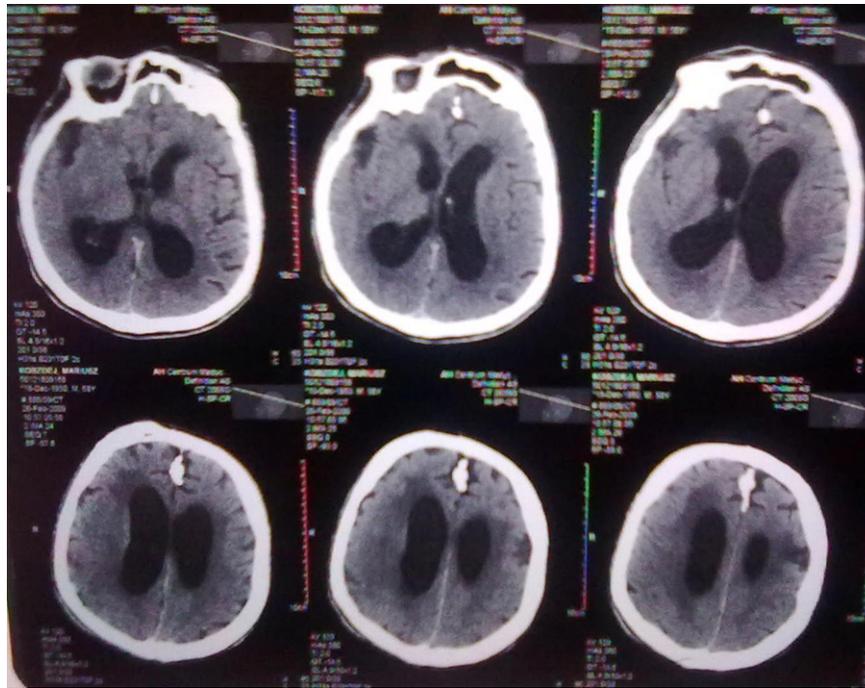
Preoperative cranial CT scan.
